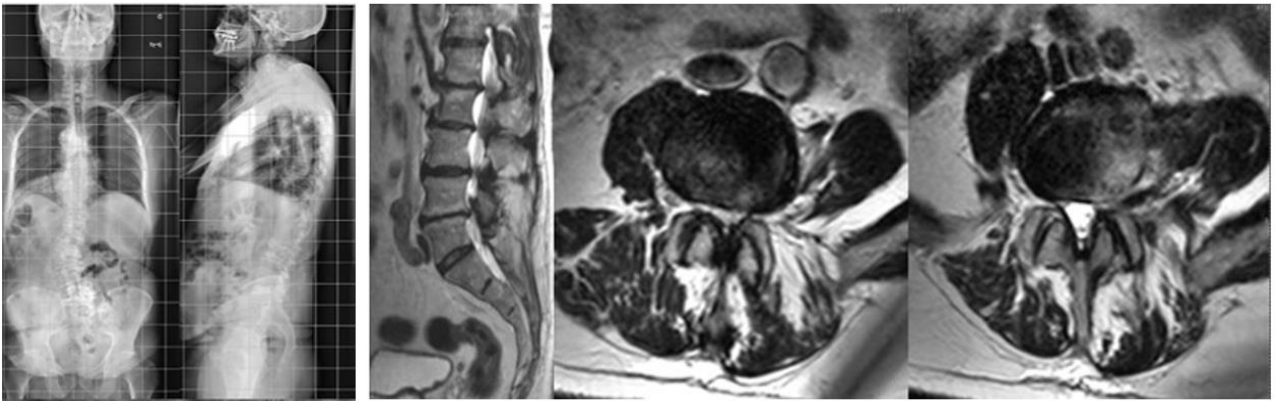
In the upper images, a full-spine radiograph demonstrates adult lumbar scoliosis. In the lower magnetic resonance imaging (MRI) images, multilevel lumbar spinal canal stenosis is observed at L3–L4 and L4–L5
